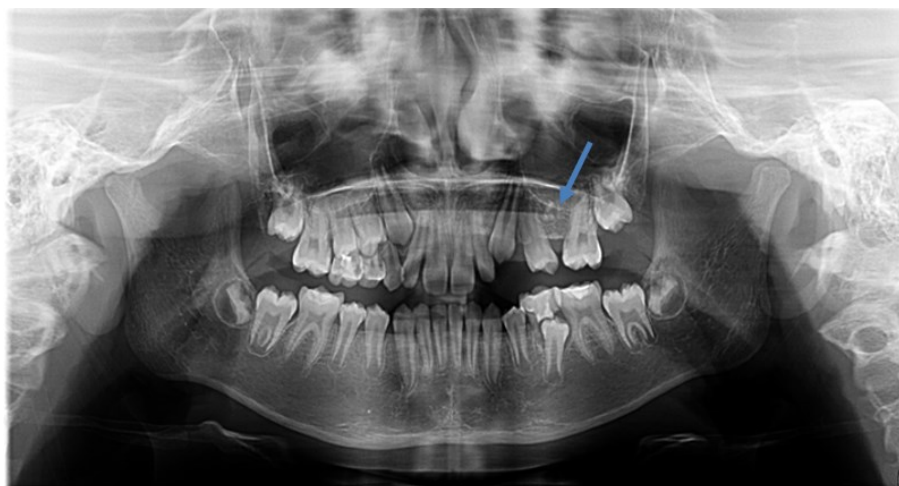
Panoramic radiograph showing tooth 25 missing, with a radiopaque lesion surrounded by a radiolucent band on the superior side
